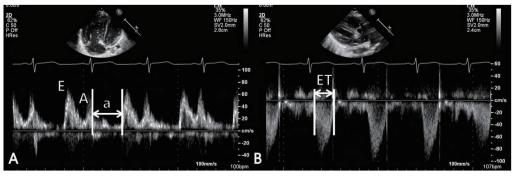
Measurement of right ventricular (RV) myocardial performance index (MPI) using pulsed-wave Doppler at the tip of tricuspid leaflets in the apical 4-chamber view (A) and at the site of just below the pulmonary valve in the RV outflow tract view (B). E, rapid filling velocity; A, atrial filling velocity; a, sum of isovolumic contraction time (IVCT), isovolumic relaxation time (IVRT) and ejection time (ET). RV MPI=(IVRT+IVCT)/ET=(a-ET)/ET.
